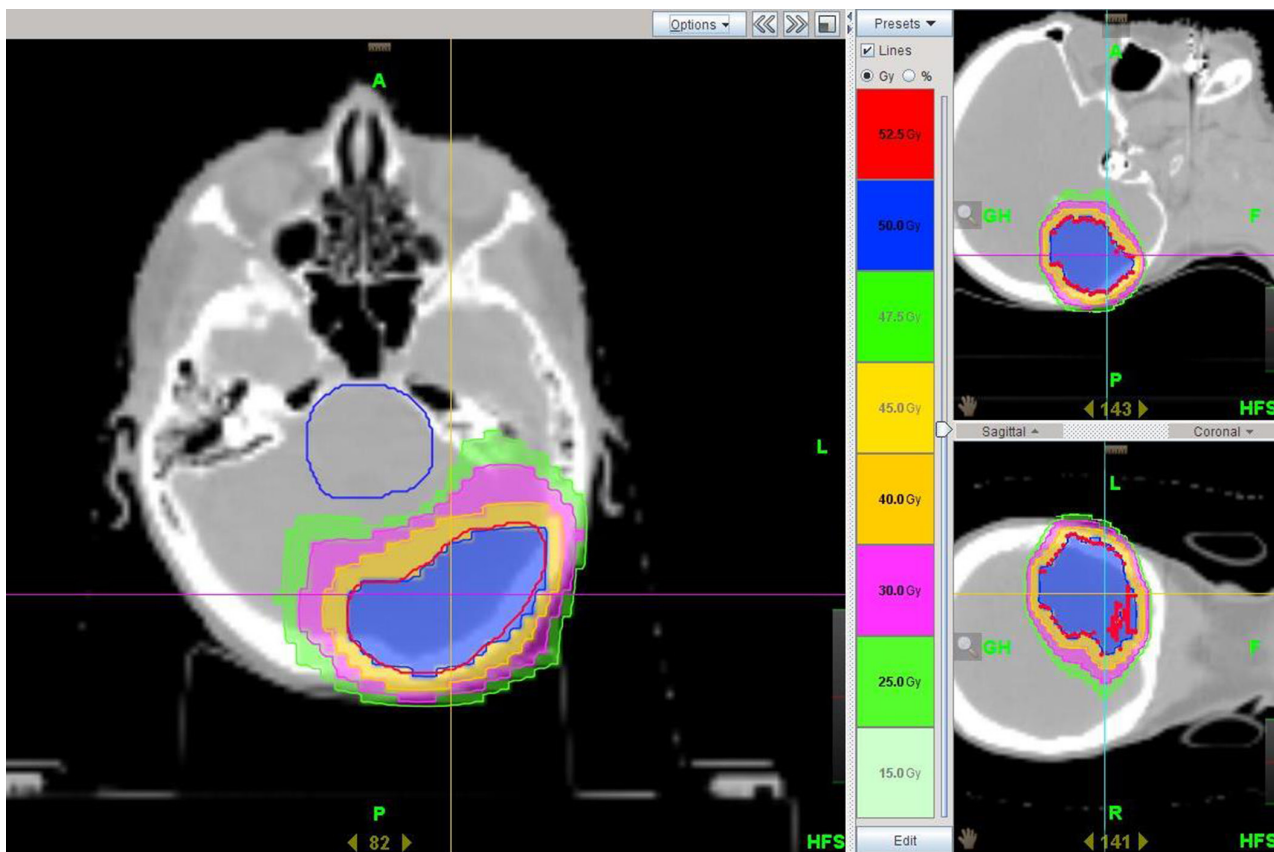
Axial, sagittal and coronal images from the treatment planning CT, showing prescription doses to tumor bed at 50 Gy (blue), 40 Gy (orange), 30 Gy (purple) and 25 Gy (green) colorwash. Note sparing of dose from the brains.
